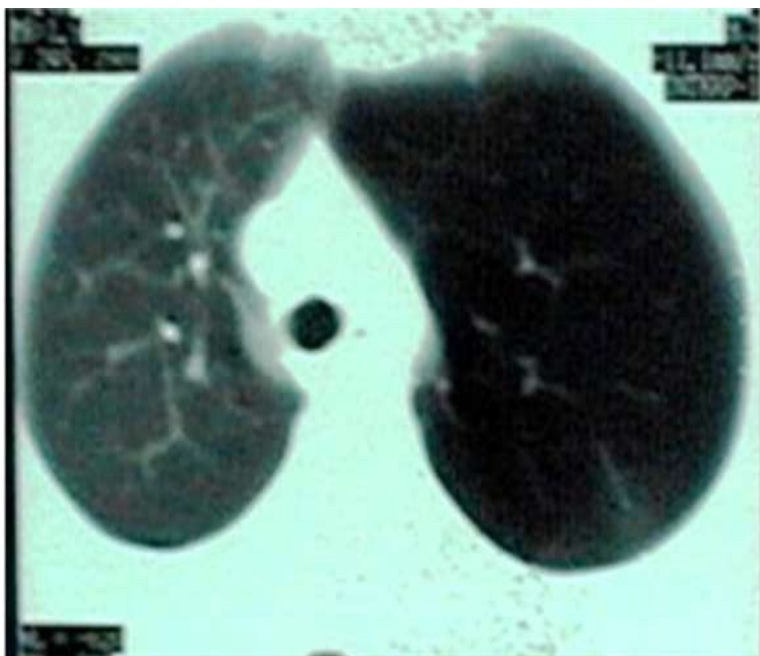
CT Scan thorax shows pan lobular and bullous emphysema of left side, relative paucity of vascular markings on left side, mediastinal shift to right and partial loss of volume of right lung
